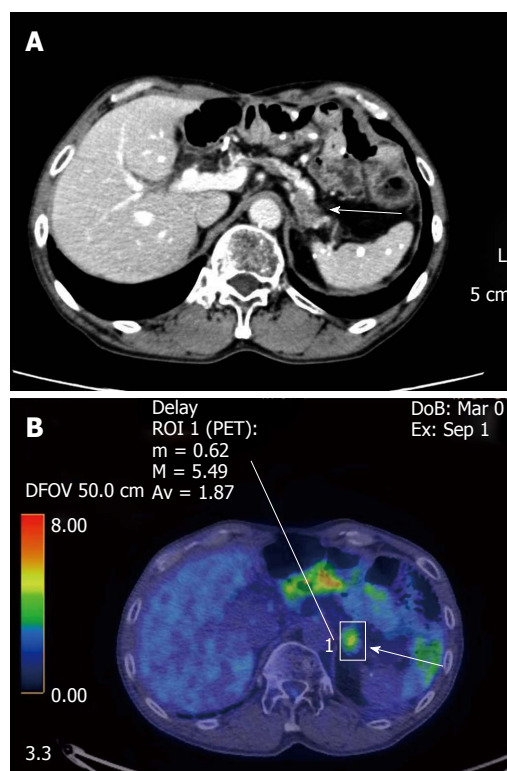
Enhanced computed tomography (A) and 18F-2-fluoro-2-deoxy-D-glucose positron-emission tomography (B) showed a tumor of the pancreatic body (arrows). The major axis of the tumor was 15 mm. Maximum standardized uptake value of the lesion was 5.49.
